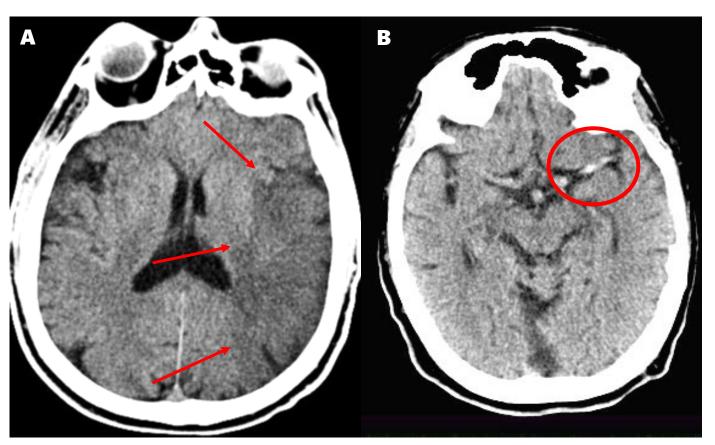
A. Acute ischemic infarct (arrows) seen as a hypoattenuating area on non-enhanced CT due to cytotoxic oedema in the left middle cerebral artery territory. B. Hyperdense left middle cerebral artery sign (circle) on non-enhanced CT corresponding to an acute thrombus.
